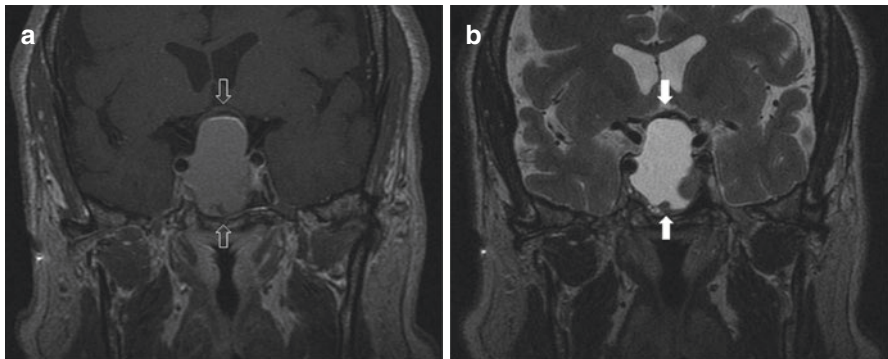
T1 (a)-weighted and T2 (b)-weighted coronal MRI images showing a large pituitary lesion with suprasellar extension. The lesion causes elevation of the optic chiasm and contacts the right and left cavernous internal carotid artery
